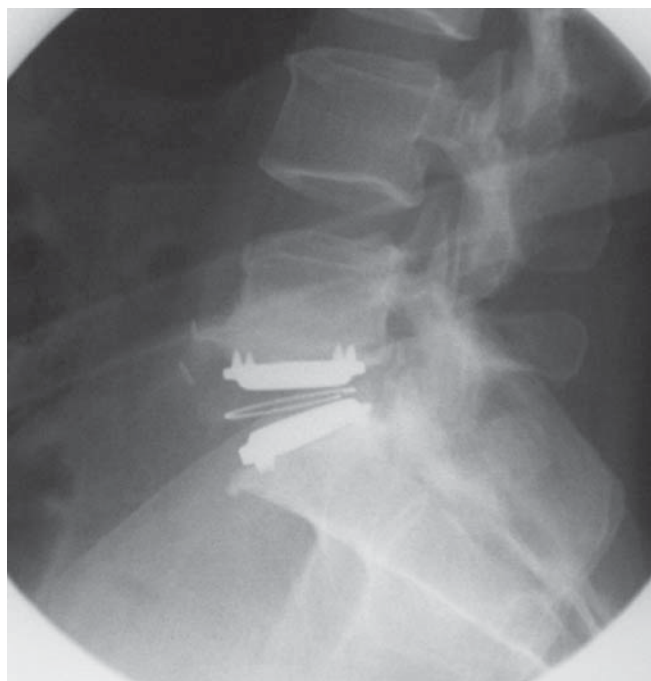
X-ray showing SB Charite' Type III disc prosthesis at L5-S1 level.
